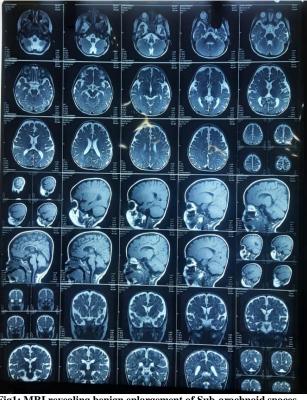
MRI revealing benign enlargement of Sub-arachnoid spaces
